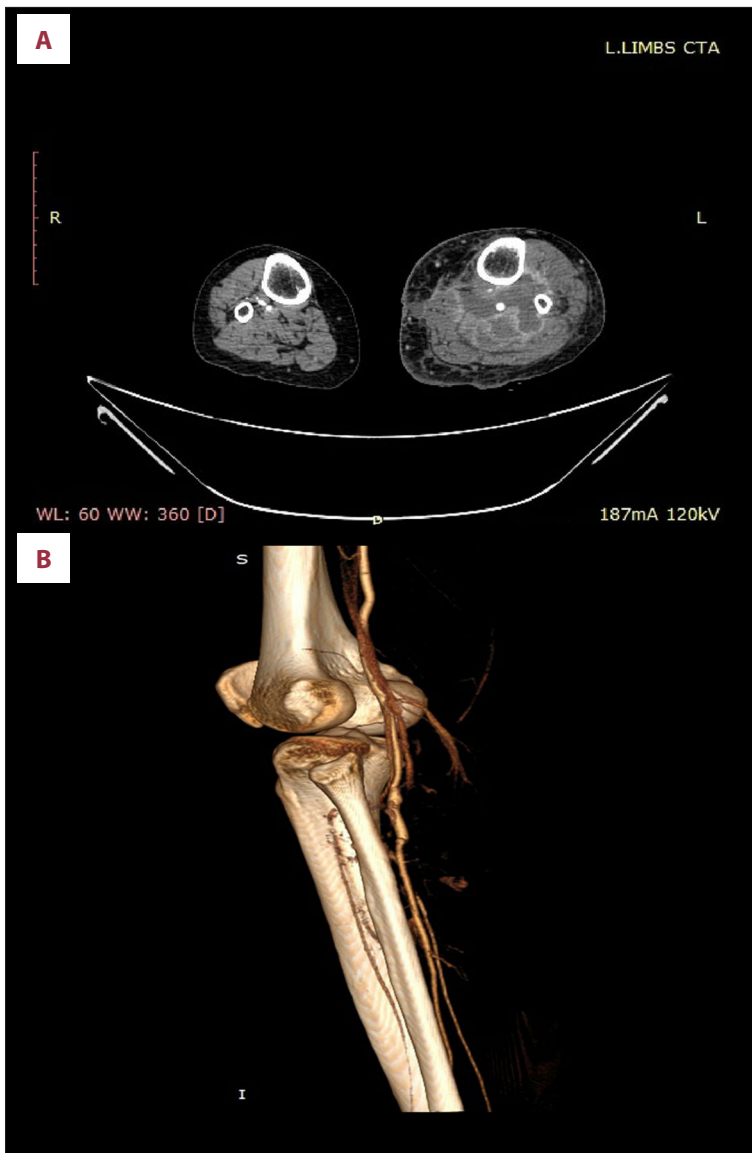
Post-operative CTA of the left lower extremity: (A) Axial image demonstrating patent interposition popliteal-PTT graft; (B) 3-D image reconstruction.
